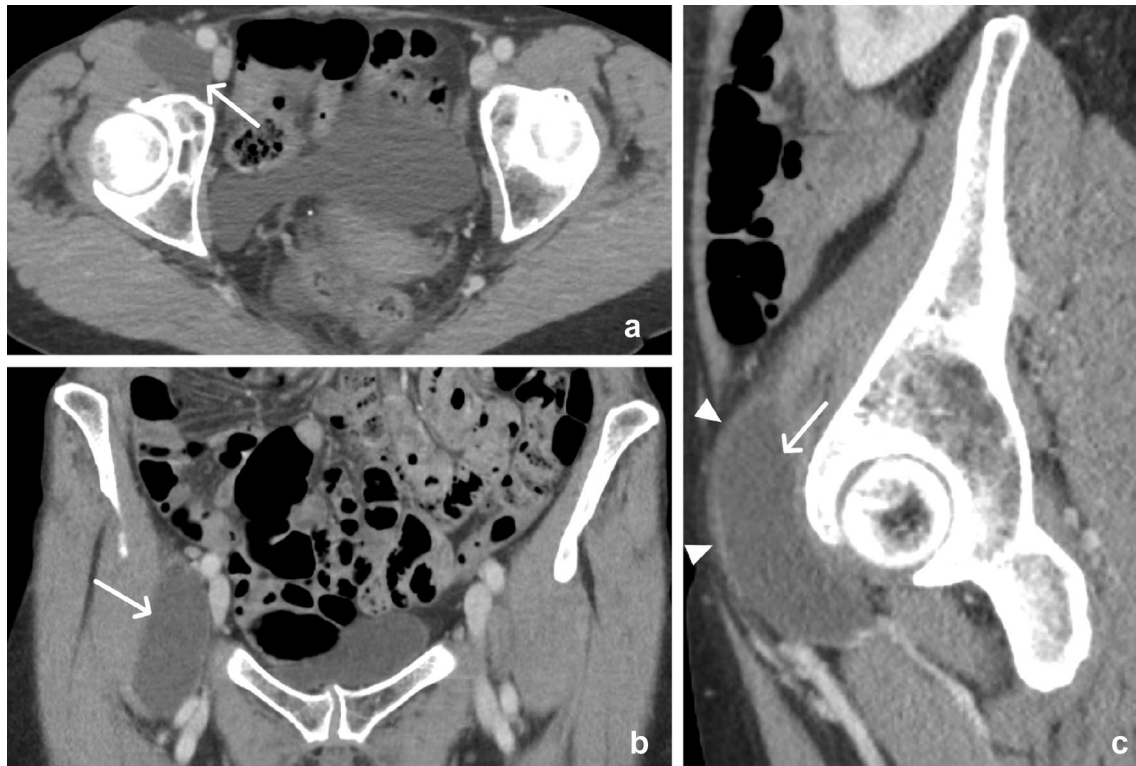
65-year-old female with iliopsoas bursitis. Axial (a), coronal (b), and sagittal (c) CT images demonstrate a well-defined cystic structure (arrows) with a thin mildly enhancing wall (arrowheads) that lies anterior to the hip joint and posteromedial to the iliopsoas muscle
